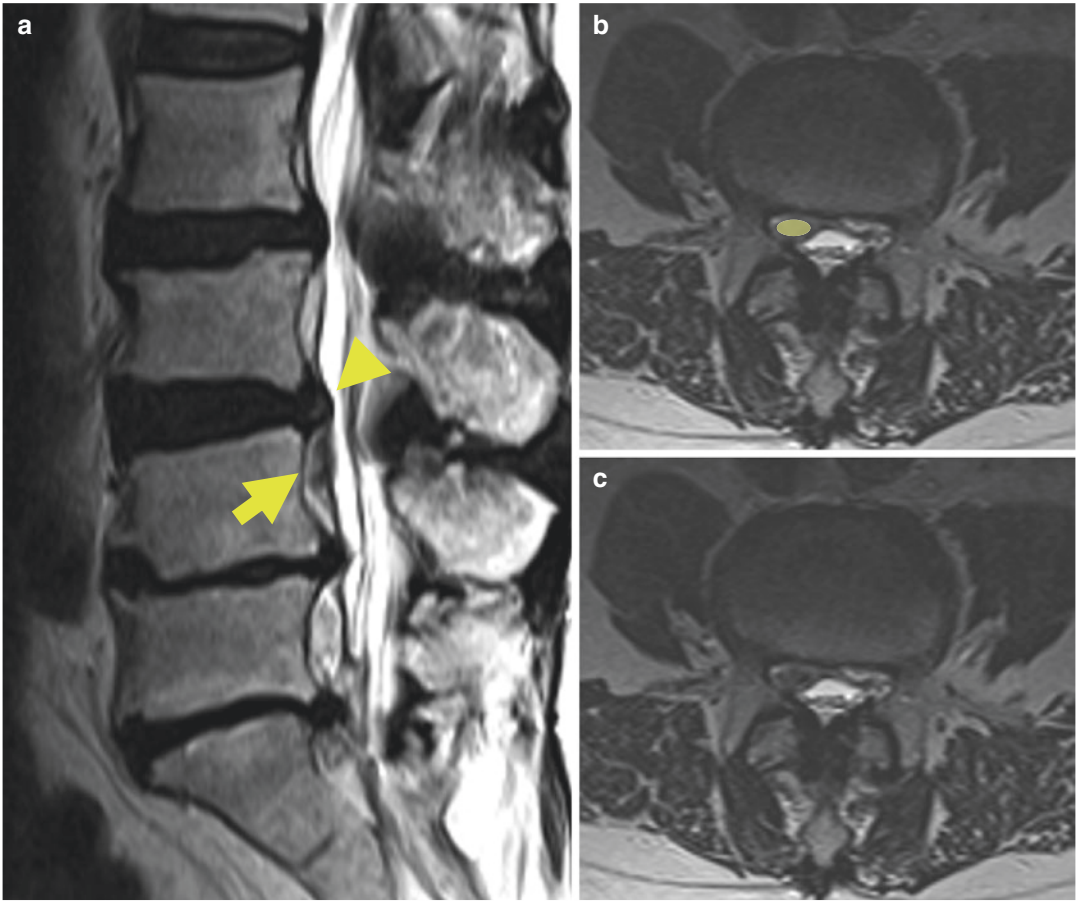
Sagittal T2-weighted (a) image of the lumbar spine demonstrates a diffuse disk bulge with a right subarticular disk herniation (arrowhead) and superimposed
